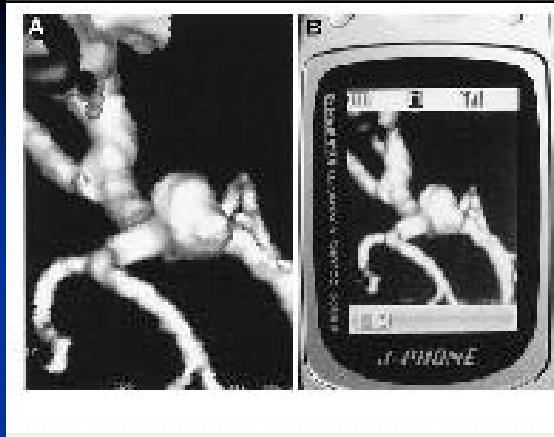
A*, original three-dimensional computed tomographic angiogram of a cerebral aneurysm. *B*, mobile phone-transmitted image.
